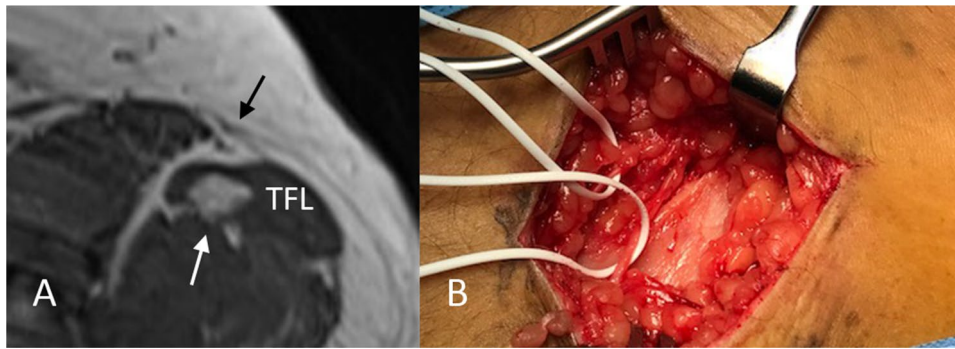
Case of lipoma inside the tensor fascia latae muscle. A: Transverse T1-weighted MR image showing a lesion of 1cm in diameter in the tensor fascia latae muscle (TFL) with high signal intensity comparable to that of subcutaneous fat (white arrow). The black arrow
